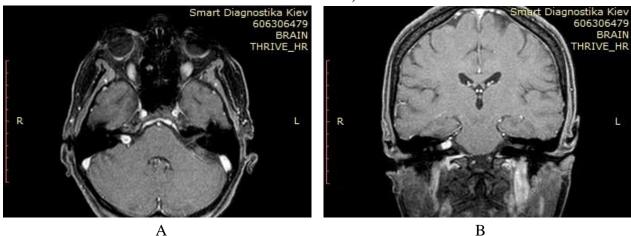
MRI images showing the location of VS in IAC: A & B - T2 images where VS is visualized in the medial and lateral portion of the IAC on the right.
